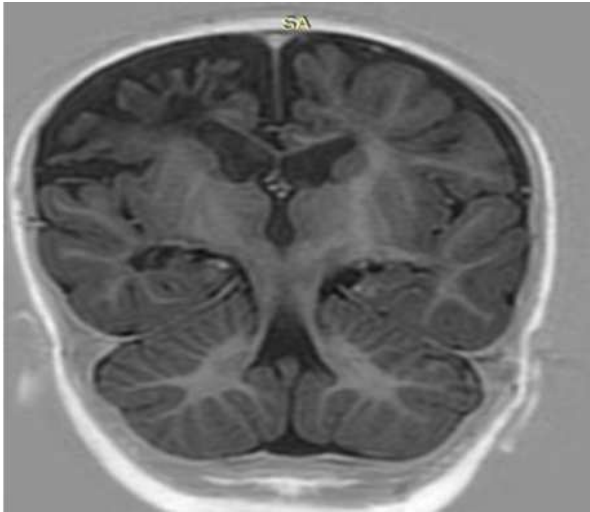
MRI Coronal section of FLAIR IR image depicting the cortical loss and structural comparison with opposite side of the cortex in case of Hypoxic ischemic encephalopathy.
